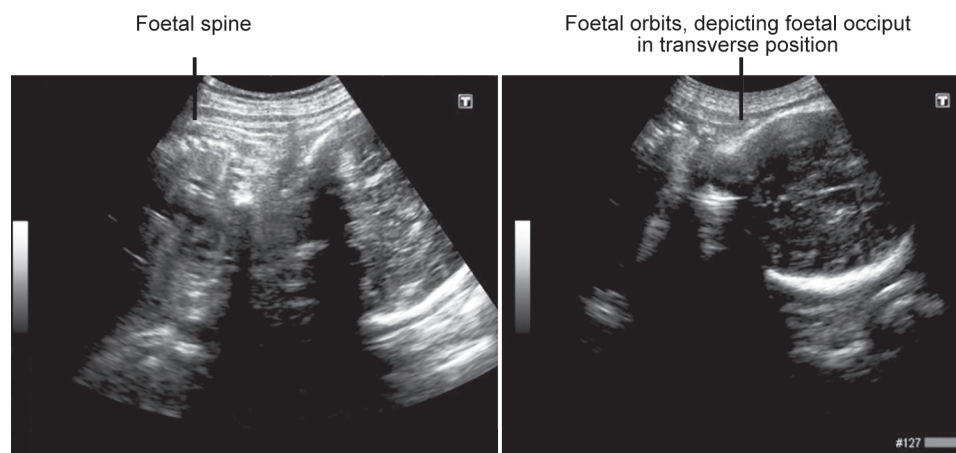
Fetal head position on transabdominal sonography
